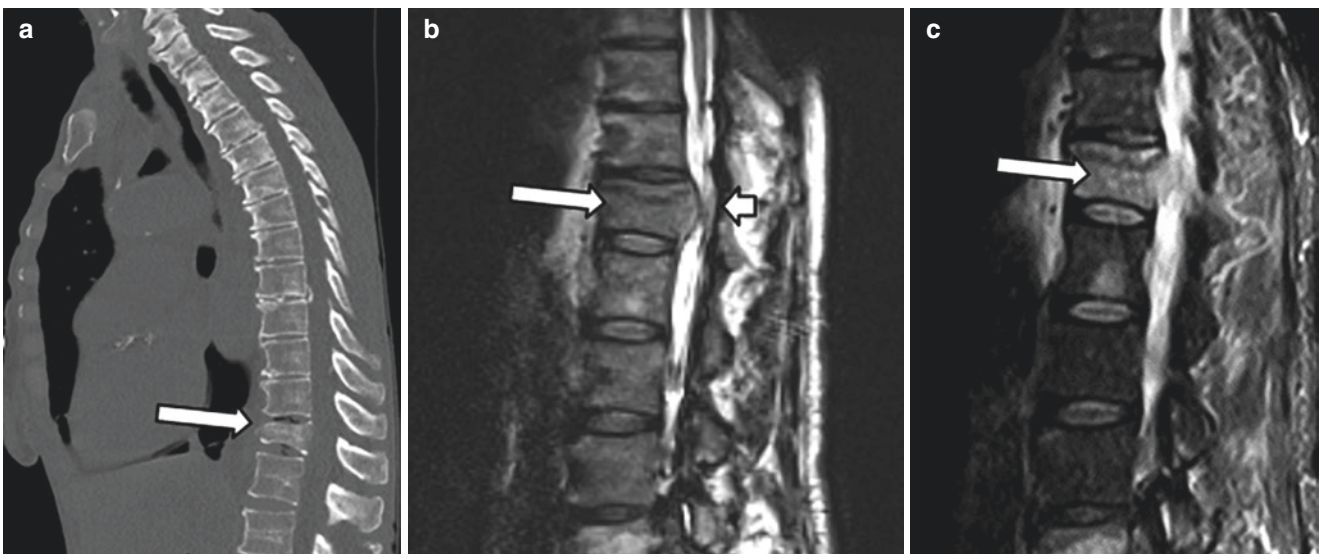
Case Study.* Imaging at follow-up patient encounter, 1 year later. Sagittal CT of the chest (a) demonstrates a wedging compression fracture of the T12 vertebral body with 50% anterior height loss (arrow); however, the age of this fracture is not definitively established
